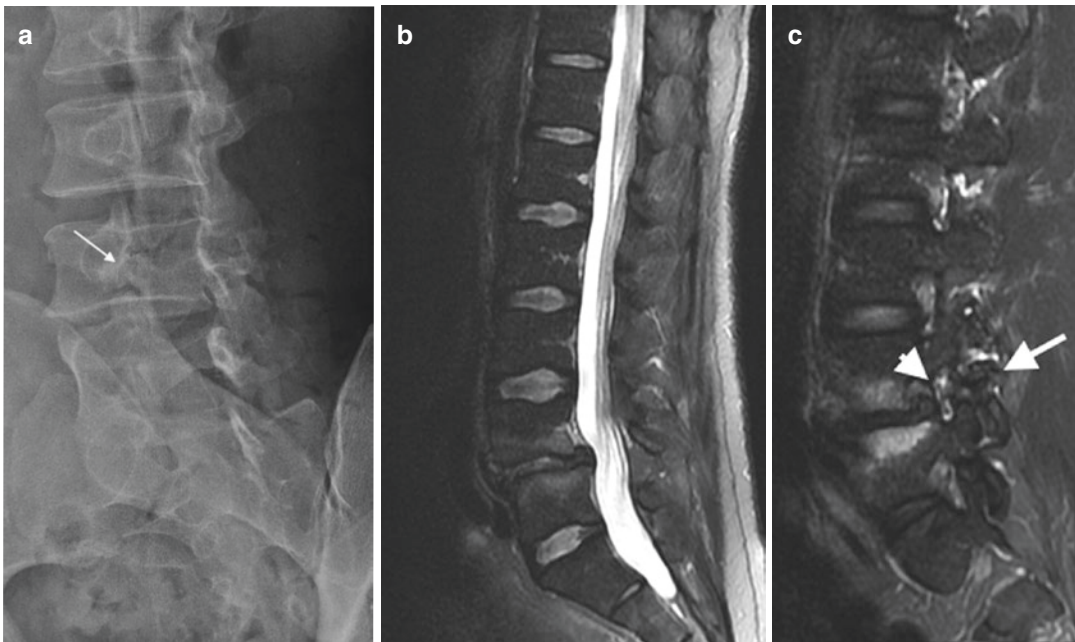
Bilateral spondylolysis and spondylolisthesis of L4 on L5: (a) oblique radiograph demonstrating spondylolysis (arrow) and (b) Sag T2FS same patient presenting 10 years later with right L4 neural impingement having developed grade 1 spondylolisthesis and (c) Sag
